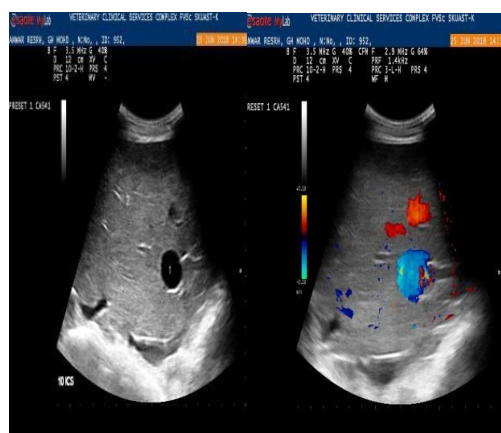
Real time ultrasonogram and Doppler view of Portal vein
